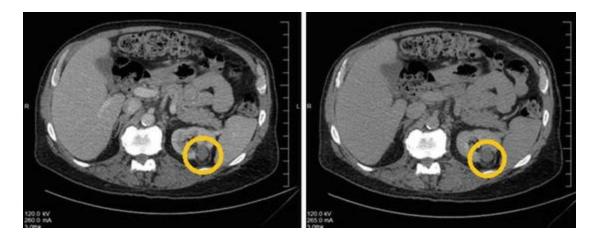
CT imaging of successful RFA, yellow circles, at 50 months post ablation
